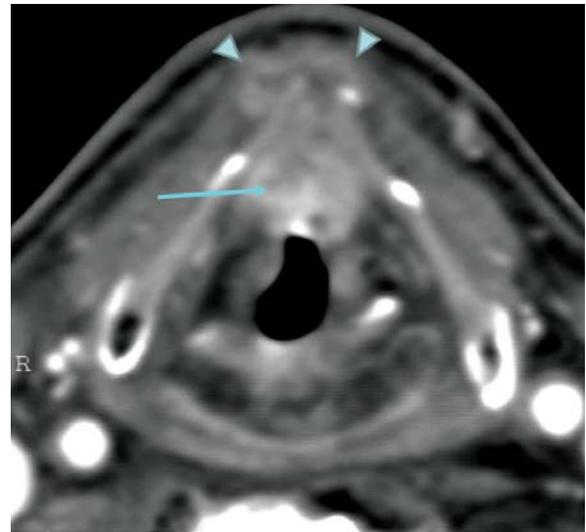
Axial CT scan through the supraglottis in a patient treated previously with radiotherapy. Recurrent lesion (arrow) is seen in the midline anteriorly with extralaryngeal spread-strap muscle infiltration (arrowheads)
